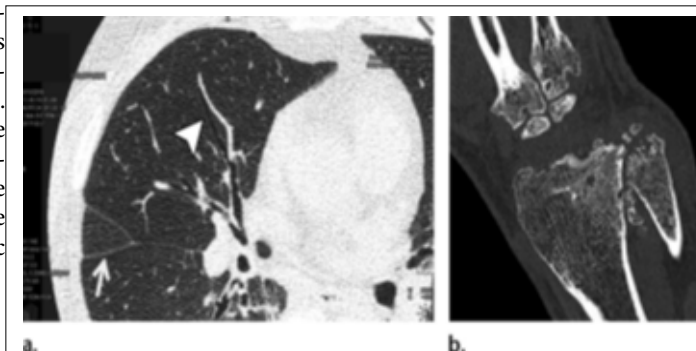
CT imaging in UHR mode. In vivo axial CT image of the lung in a 69 year old woman (a) and coronal CT image of the wrist (b) show that high spatial resolution enables accurate delineation of lung fissures (arrow in a), airway walls (arrowhead in a), and trabecular bone (Leng et al. 2019).
